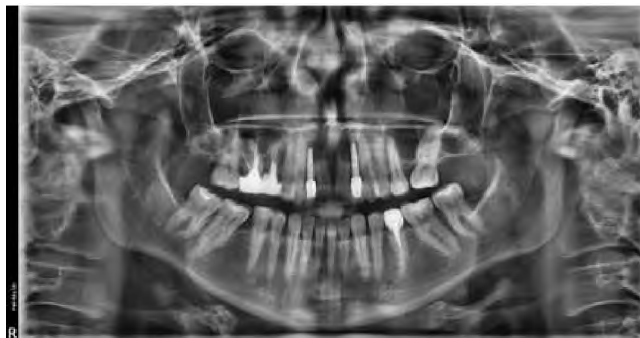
The final X-ray.
